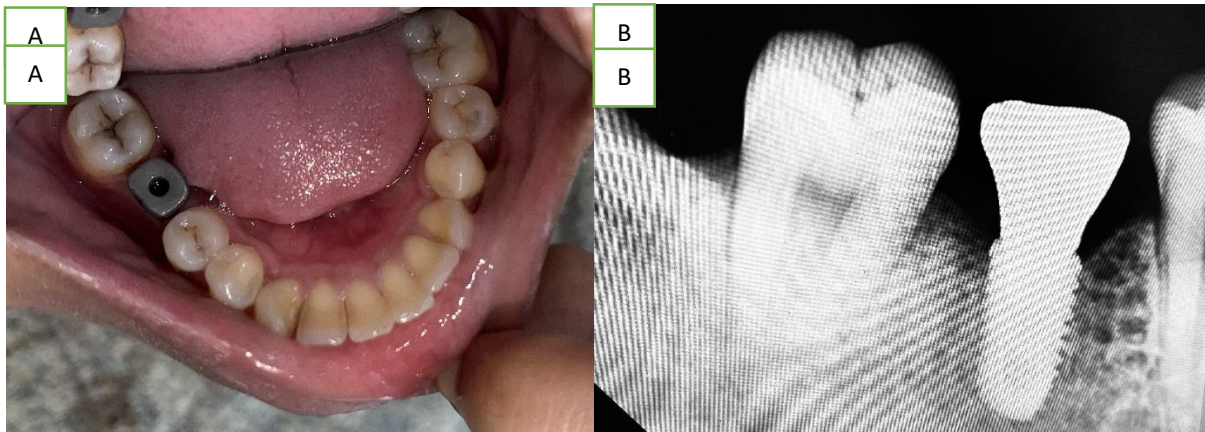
metal try in A) intra-orally B) in intra-oral periapical radiograph
